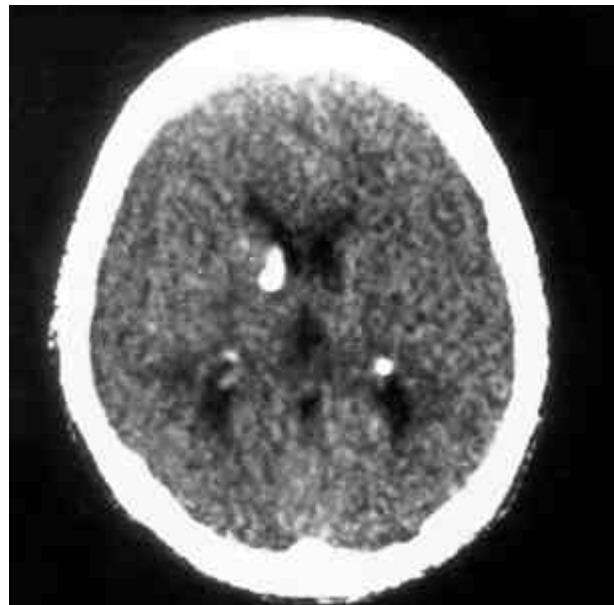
Computed tomography of the brain. Multiple calcific nodules are noted at the subependymal region.
